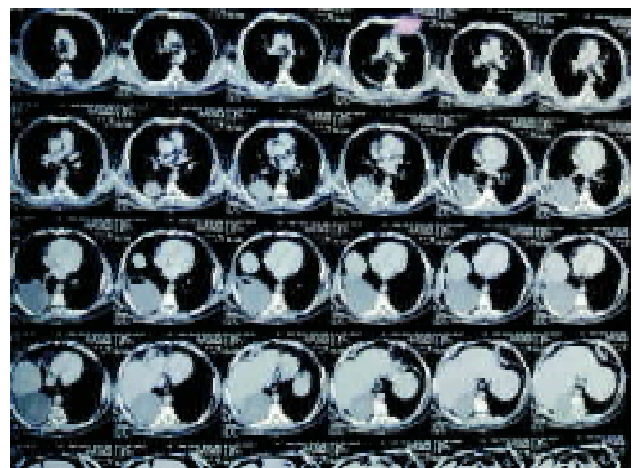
Pre-procedural CT scan localising the haemothorax.
